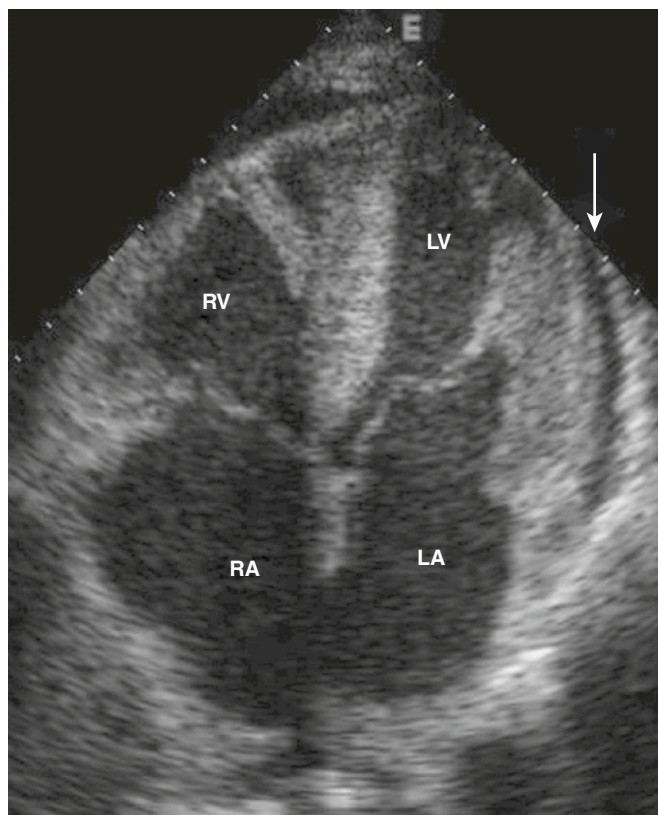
Echocardiogram of a patient with primary amyloidosis shows a pericardial effusion (arrow), hyperechoic muscular hypertrophy, and dilatation of the right atrium (RA) and right ventricle (RV). LA, left atrium; LV, left ventricle.
